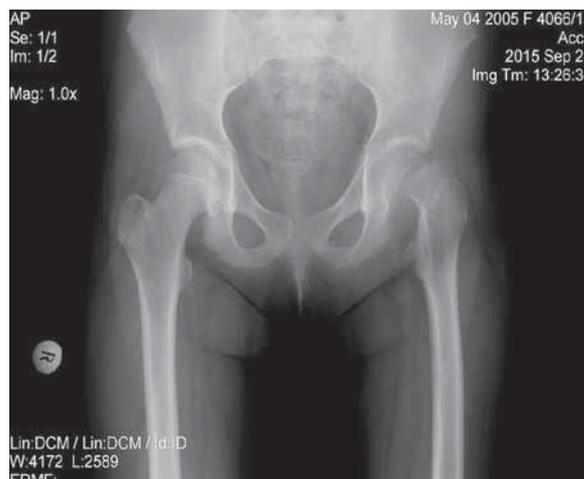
Patient M. before treatment: radiograph of the hip joints before surgery in a frontal projection: the total solution of continuity of the neck of the left femur in the subcapital zone with fragment displacement
